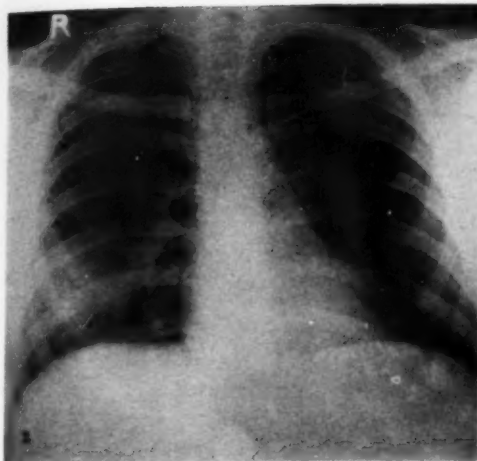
Roentgenogram of the government inspector, showing a circumscribed area of infiltration with poorly defined margins.
